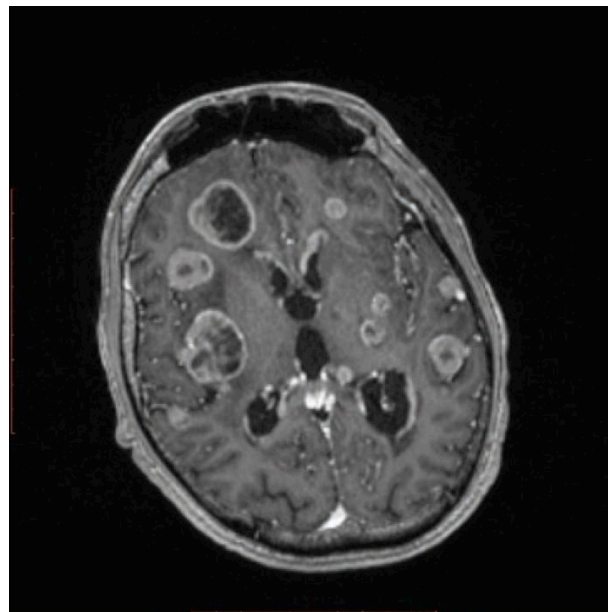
Multiple brain abscesses with marginal contrast enhancement-contrast enhanced T1 MRI, July 2017
